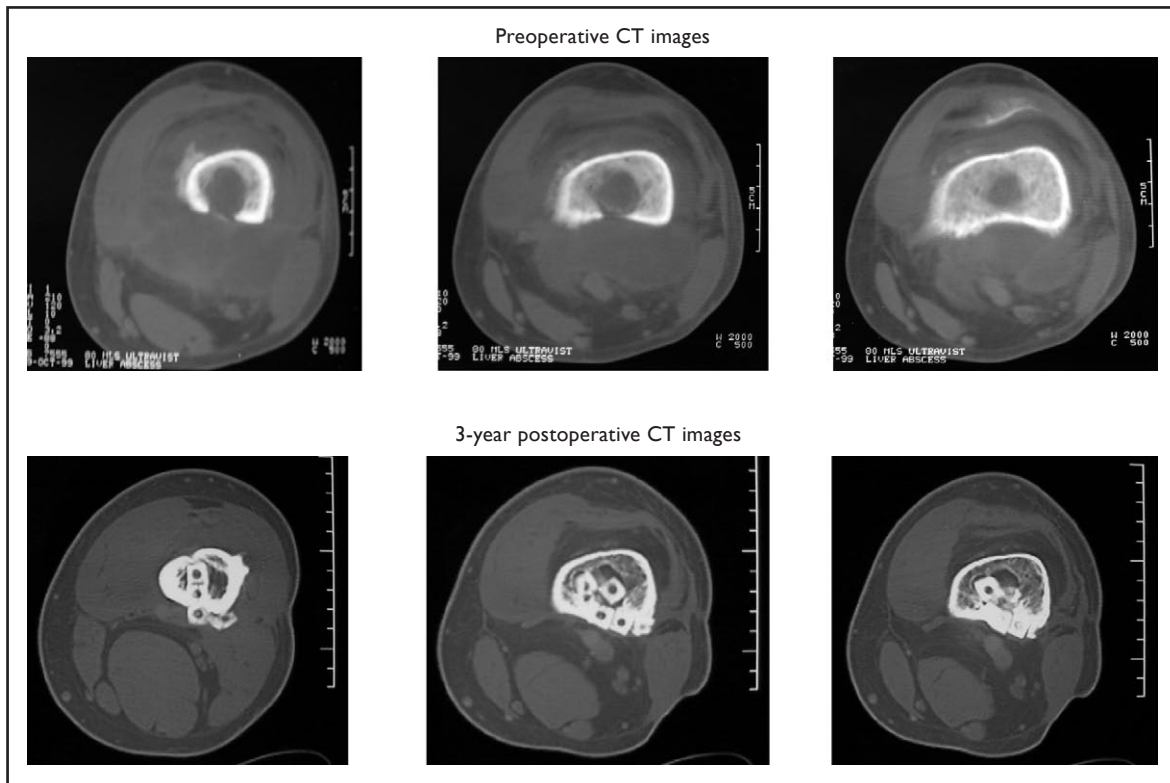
The preoperative CT images (top row) show features of osteomyelitis evidenced by periosteal reaction with subperiosteal collection, especially over the posterior aspect of the distal left femur. The three-year postoperative CT images (bottom row) show resolution of the osteomyelitis with incorporation of the calcium hydroxyapatite into host bone.
